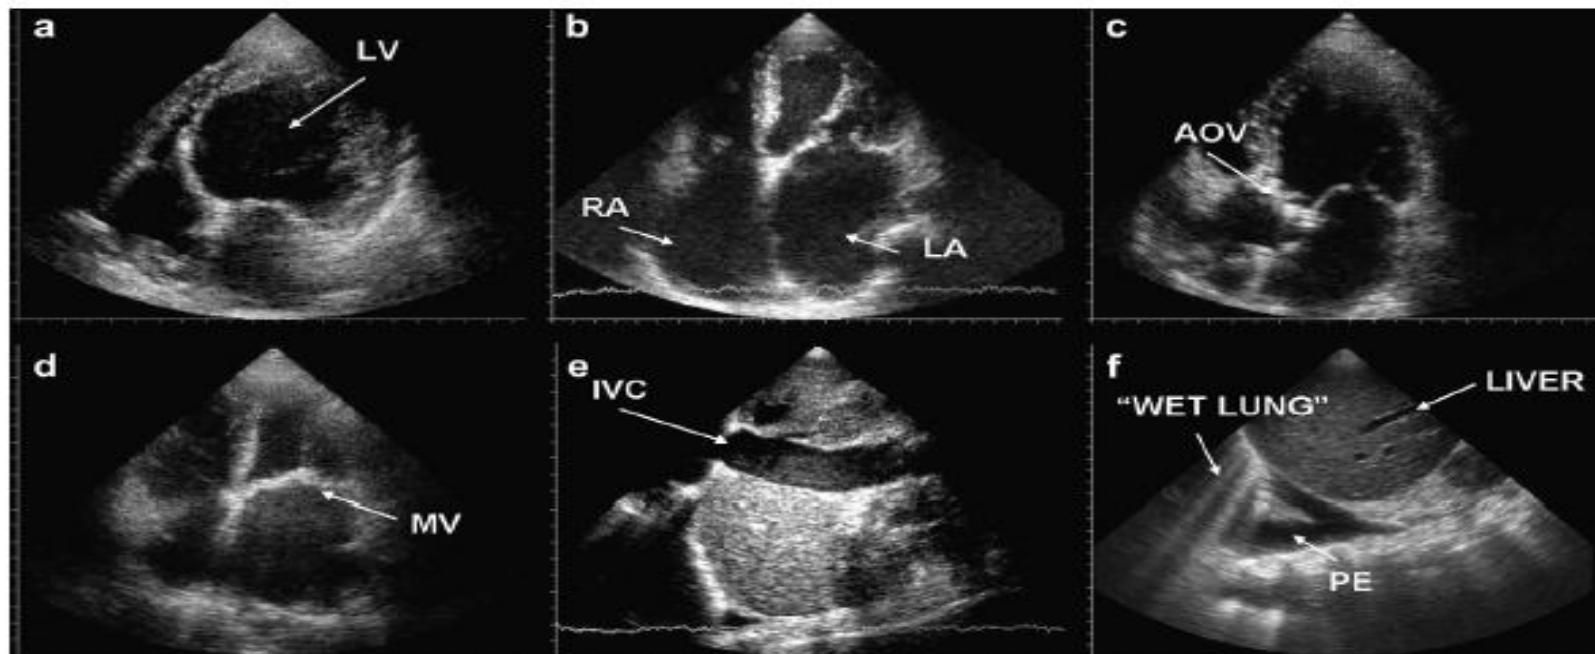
Possible echocardiographic findings in cardiogenic shock. (a) LV dilatation in a patient with severe systolic dysfunction, (b) important atrial dilatation in a patient with diastolic dysfunction, (c) aortic valve stenosis, (d) mitral valve stenosis, (e) dilated IVC, (f) "wet lung" and pleural effusion. LV = left ventricle; RA = right atrium; LA = left atrium; AOV = aortic valve; MV = mitral valve; IVC = inferior vena cava; PE = pleural effusion.
